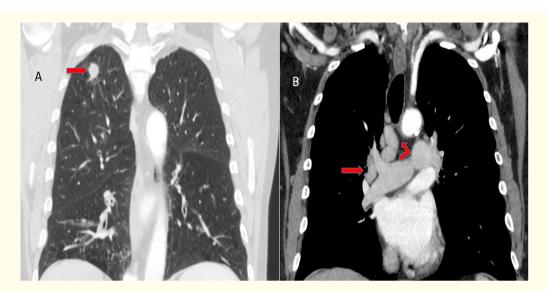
Coronal view of the patient #1 CT chest with contrast at presentation. Panel A, lung window, shows the spiculated right upper lung nodule (arrow). Panel B, mediastinal window, shows the enlarged mediastinal (double arrow) and right hilar lymphadenopathy (single arrow).
